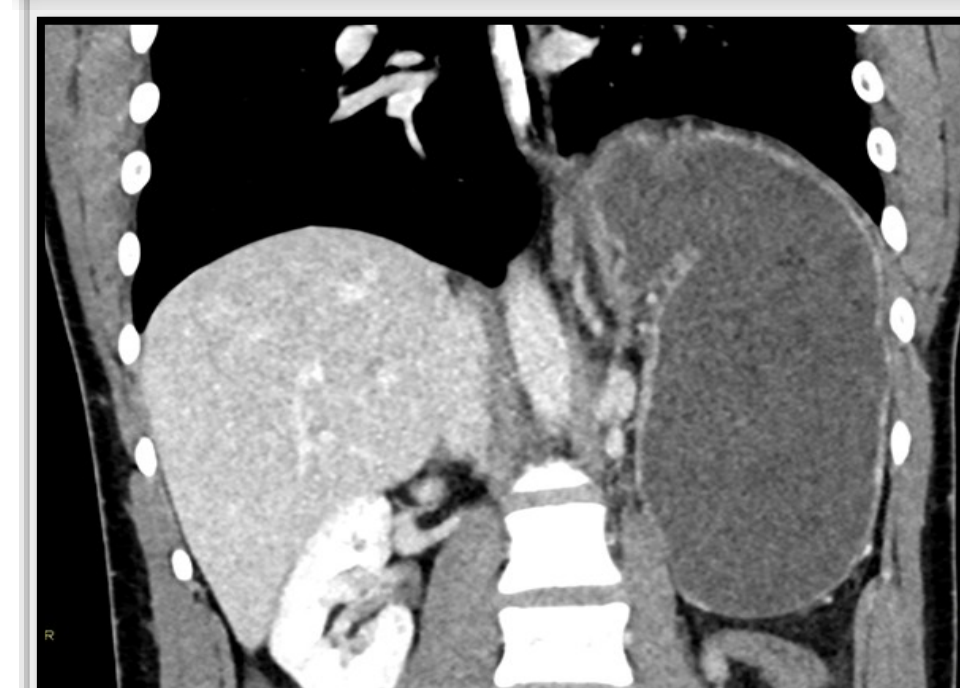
Coronal CT reconstruction demonstrating superior displacement of the gastric antrum relative to the fundus, consistent with mesenteroaxial rotation.
